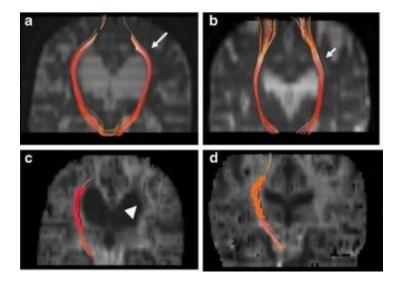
Anisotropy color-coded MRI tractography of the corticospinal tract (CST) at the level of the lateral ventricle (arrows) (a) in a patient with idiopathic normal pressure hydrocephalus (iNPH) and (b) in a control subject. These tractography on coronal mean kurtos Is images are shown without diffusion encoding images (b=0s/mm2). Diffusional kurtosis images of (c) the iNPH patient and (d) the control subject. The diffusional kurtosis images of the iNPH patient (c) shows the relative low intensity (arrow head) of the periventricular areascompared to control subjects (d).
